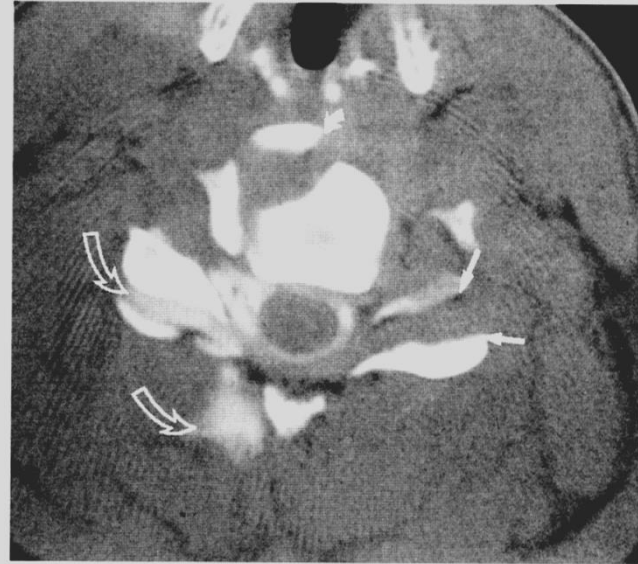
Fracture-dislocation of cervical spine with dural tear. Axial postmyelography CT image through the C5-6 disc. Fractures of the vertebral body (solid curved arrows) and widening of the facet joint space (straight arrows) can be seen. Leakage of myelographic contrast into the right C5-6 facet joint space and leakage into the posterior paraspinal soft tissues indicate a dural tear (open curved arrows).
